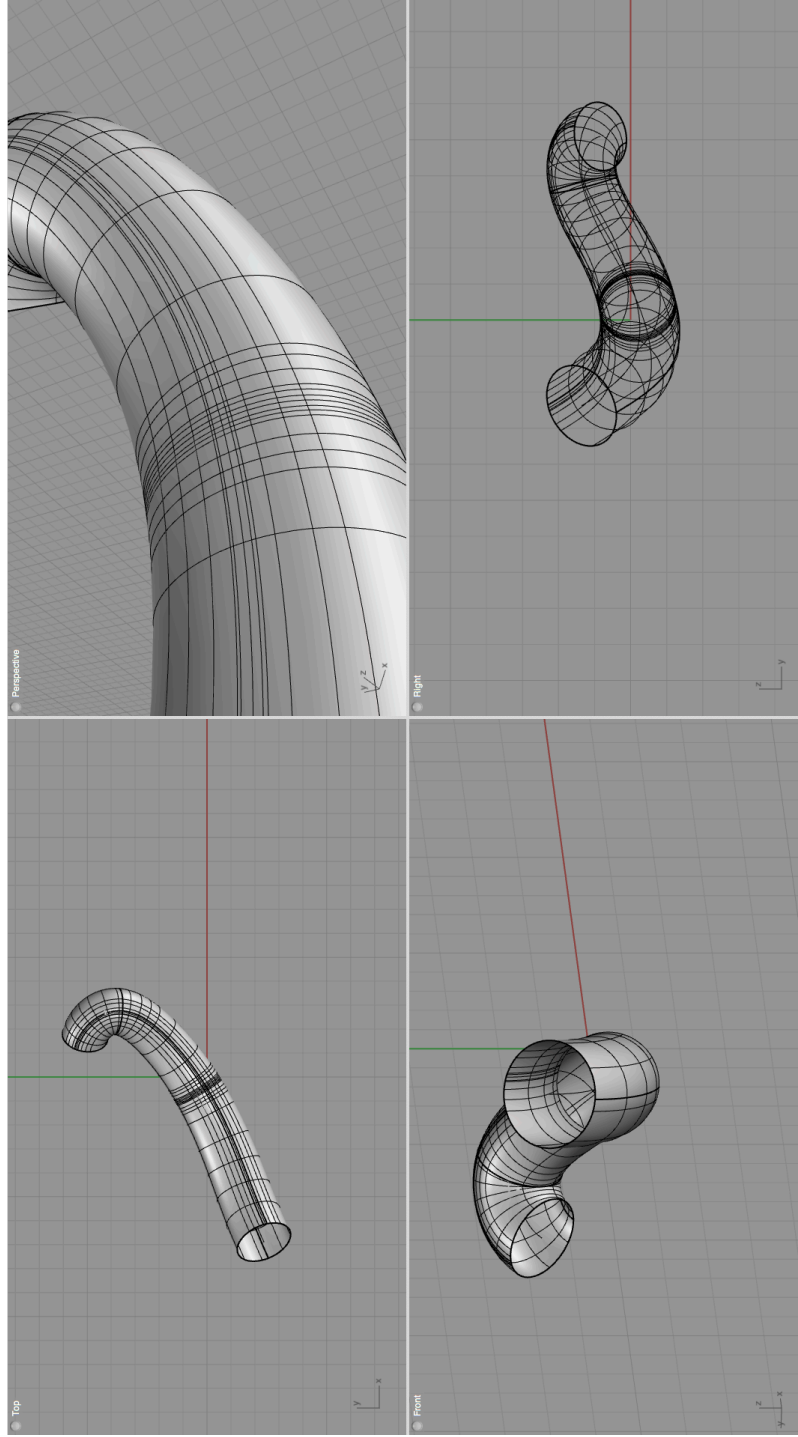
Four views of the healthy geometry. This is a freehand NURBS model using the 3D CAD software package Rhinoceros. The parent artery geometry and aneurysm geometries were identified and made from cranial CT data of the author. Research tools are being developed to fully automate this process.
